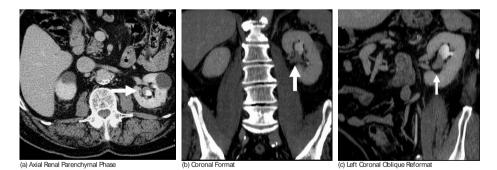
Selected images from a CT Urography protocol CT. 8a is an axial CT image from the renal parenchymal phase. There is a mildly enhancing soft tissue mass in the left renal pelvis (arrow) consistent with a transitional cell carcinoma. Figure 8b (coronal reformats) and 8c (left oblique coronal reformats) demonstrate the double bolus technique of CT Urography. These images confirm soft tissue mass (arrows) in the renal pelvis with contrast excretion into the collecting system (arrowheads).
